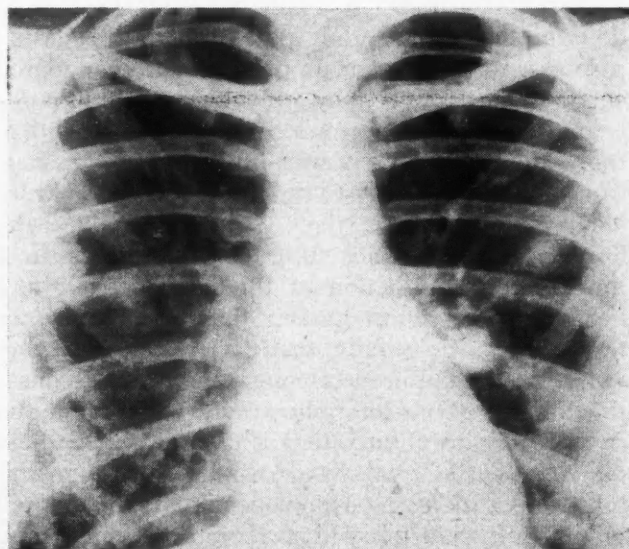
Chest roentgenogram taken May 21, 1952.
